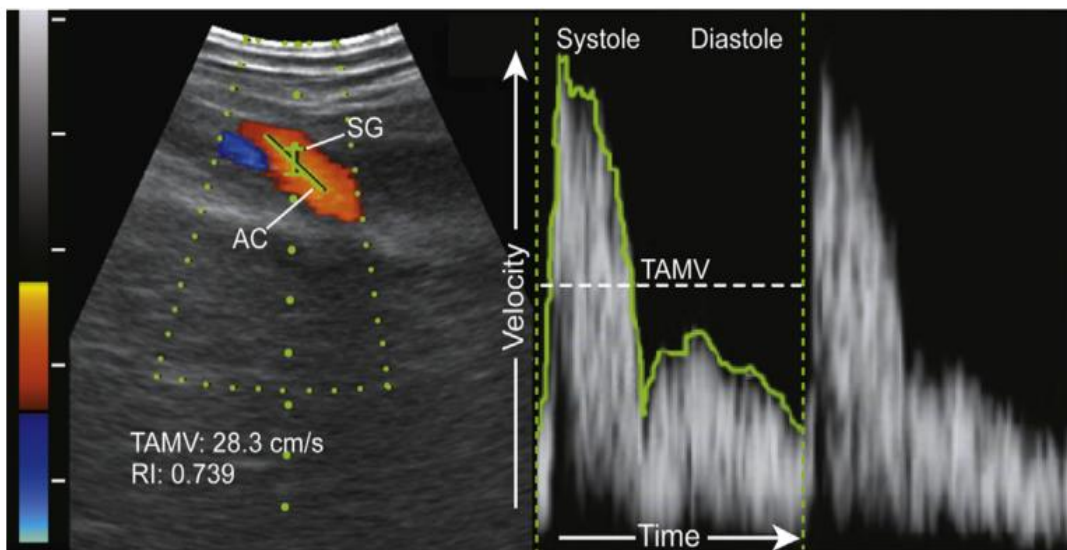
Color-Doppler ultrasound of an artery during an individual cardiac pulse.
